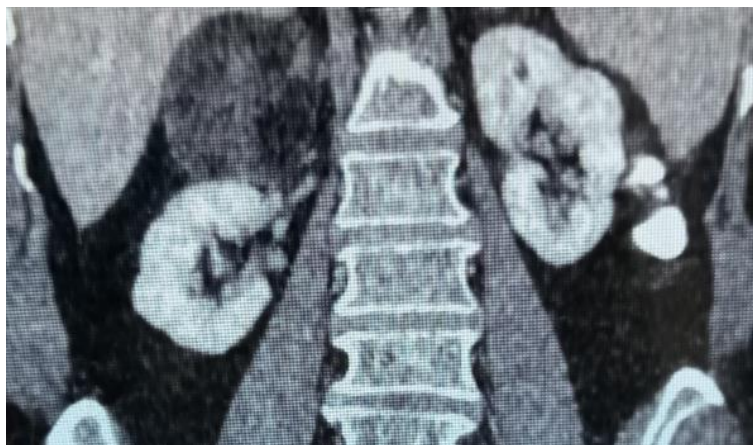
CT abdomen: Bulky and enlarged right adrenal gland revealed well defined fat density lesion
